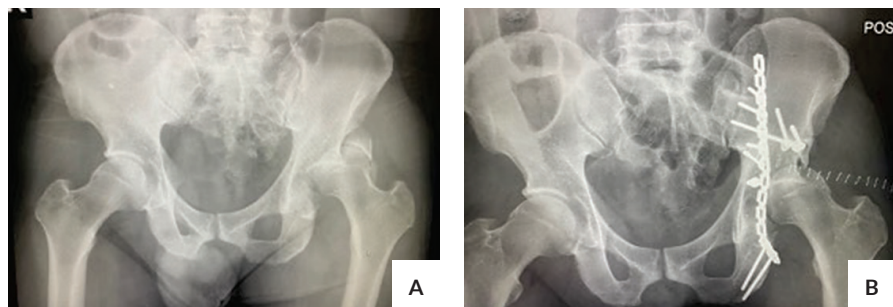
Radiographs from Patient 1 – Male, 41-year-old, car accident. (A) Preoperative, (B) Immediate post-operative, (C) Revision, (D) 1 year post-operative.
